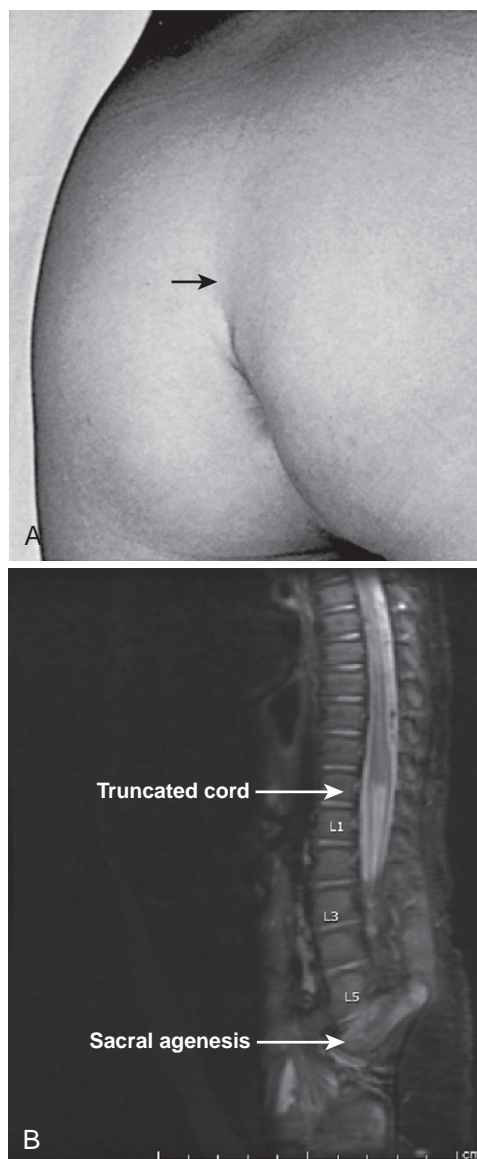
A, Photograph of buttocks of patient with sacral agenesis. Note flattened buttocks and a low, short gluteal cleft. B, Magnetic resonance imaging of the lumbosacral spine in patient with sacral agenesis. Note sharp cutoff of the conus at T12 (arrow).
